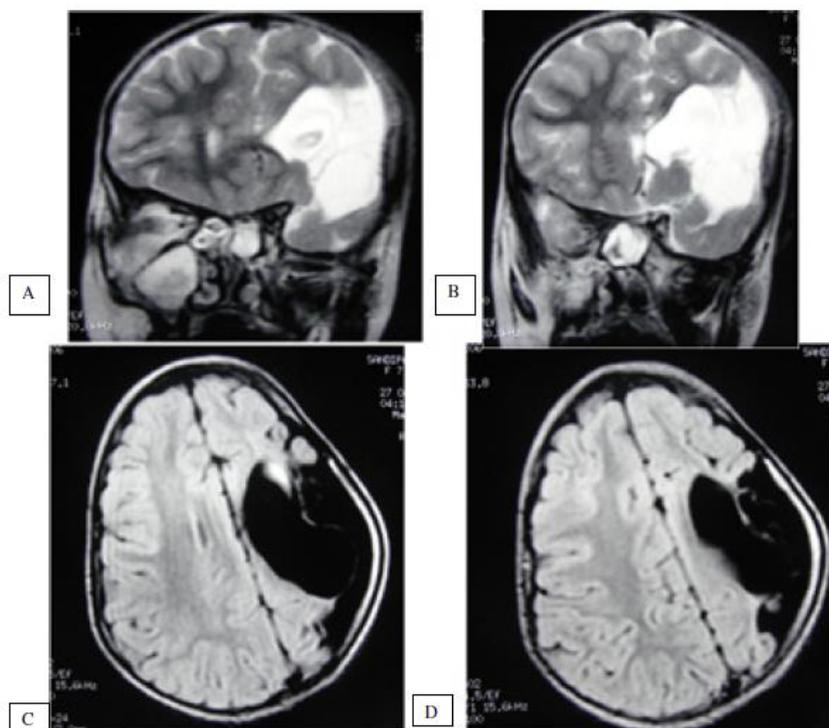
MRI different sequences A, B – Coronal T2 weighted sequences, C,D- Axial FLAIR sequences showing left sided hemiatrophy, encephalomalacia and porencephalic dilatation of lateral ventricle
